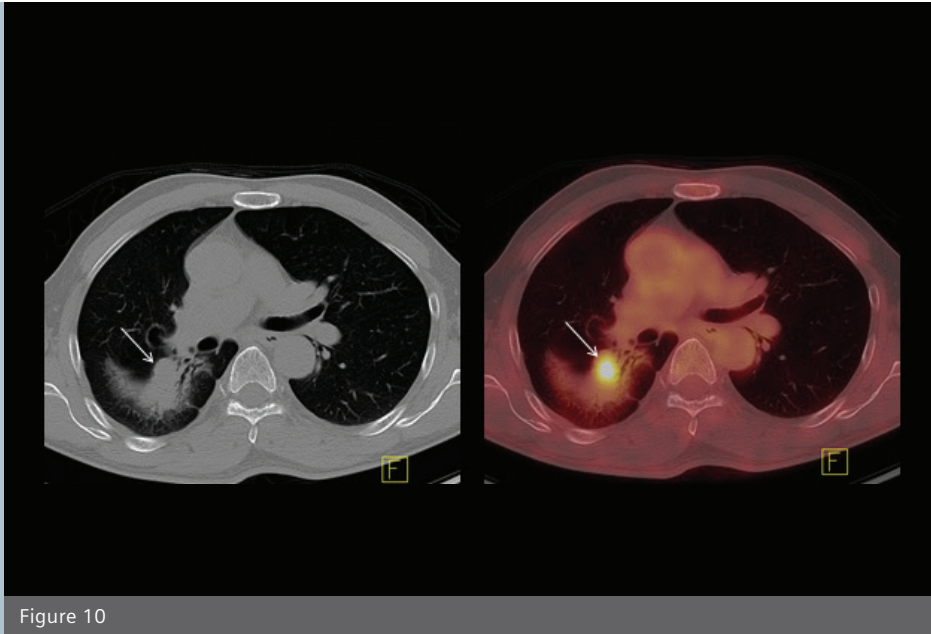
Recurrence of lung carcinoma within a region with post-radiation fibrosis. ^{18}F FDG PET shows hypermetabolism within recurrent tumor (white arrow) with adjacent fibrotic changes secondary to radiation therapy visualized on CT and showing low ^{18}F FDG uptake on PET/CT. ^{18}F FDG PET/CT delineates the extent of recurrent tumor and differentiates tumor margins from adjacent post-radiation fibrosis.
